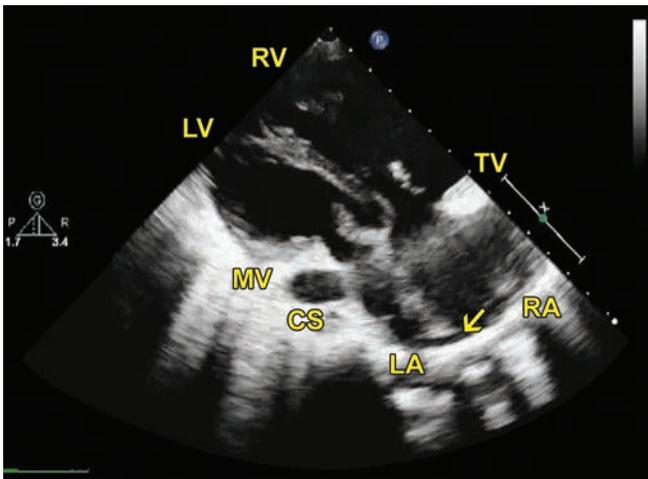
The arrow in the left parasternal view demonstrates the sinus venosus ASD and an enlarged coronary sinus (CS).
